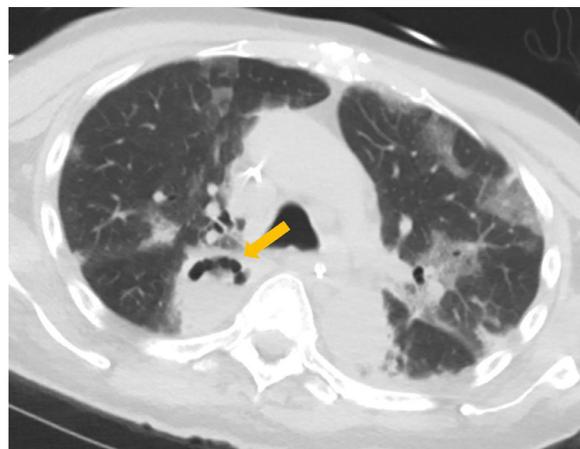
Axial CT demonstrates moderate severity of ground-glass opacities with a perilobular and peripheral lung distribution. In addition, there is a lung abscess (arrow) within the medial right lower lobe, for which a superimposed bacterial infection should be considered.
